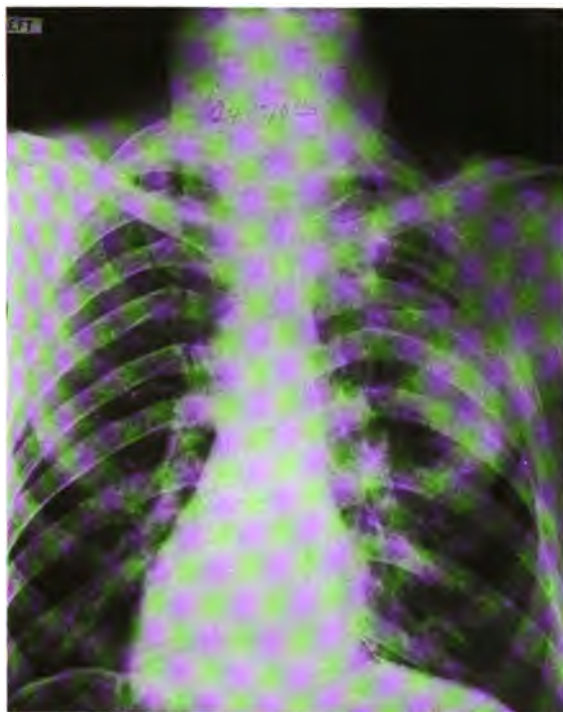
(240703).—Roentgenogram made before operation about two and one-half months after teeth extraction. Note the fluid level.
